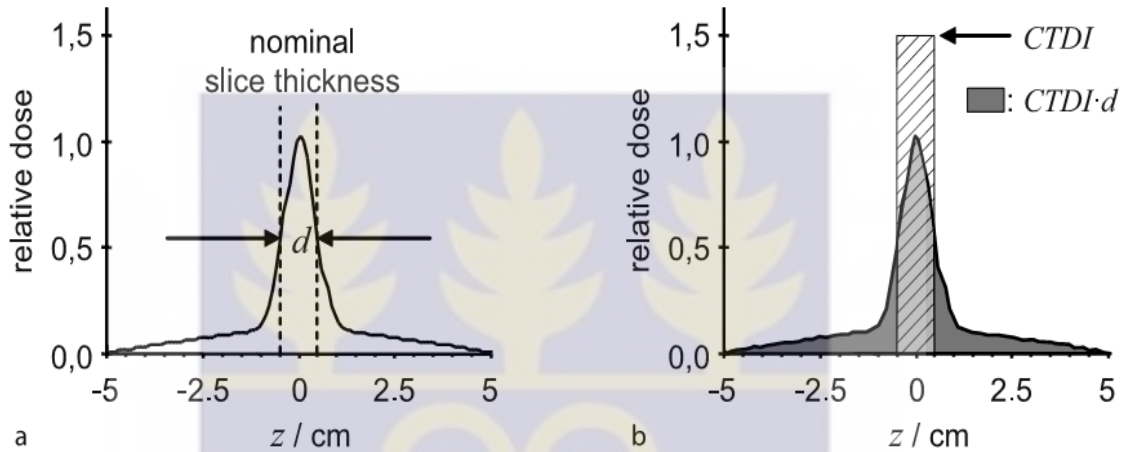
(a) Single slice dose profile for a nominal slice thickness d and (b) How Computed tomography dose index (CTDI) is obtained through the area of dose profile for a certain slice thickness.
